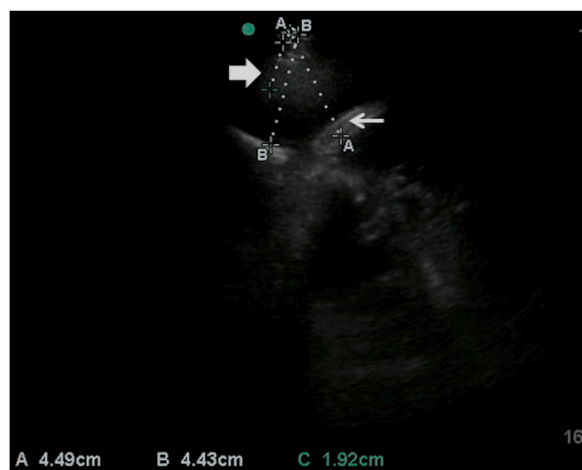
Lung ultrasound. Diaphragm (narrow white arrow), pleural nodule (thick white arrow). Distance measurements are represented by the dotted lines: (A) skin to diaphragm, (B) skin to lung, (C) size of lung nodule. Diaphragm thickness is > 1 cm, which has a high diagnostic sensitivity for the presence of a malignant pleural effusion regardless of if cytology is negative.
